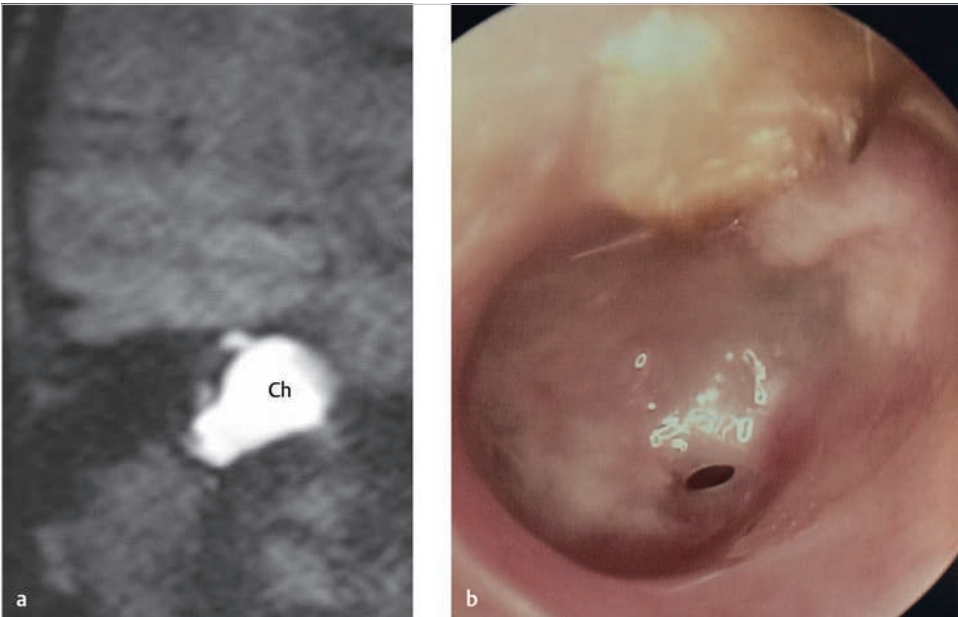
A very high signal in a coronal section of diffusion-weighted image MRI (a) indicated presence of cholesteatoma in the petrous apex. In spite of such extensive involvement of the temporal bone, a small perforation in the inflamed tympanic membrane is the only finding obtained under otoscopic examination (b). Ch, cholesteatoma.
